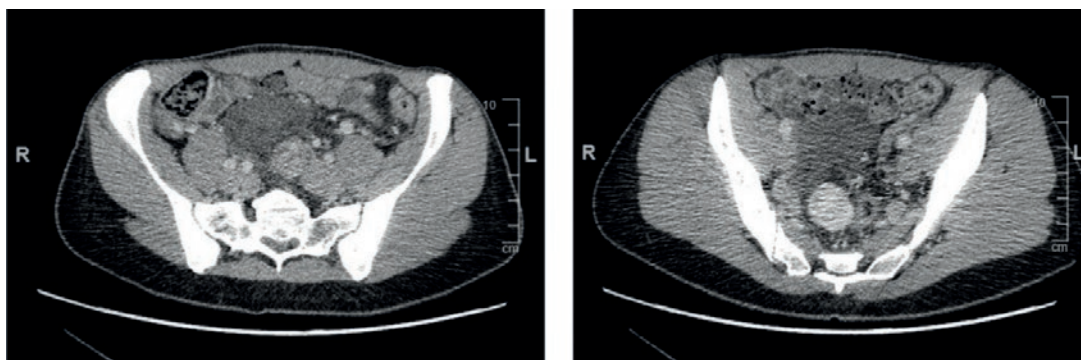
Baseline computed tomography scan (February 2013).
